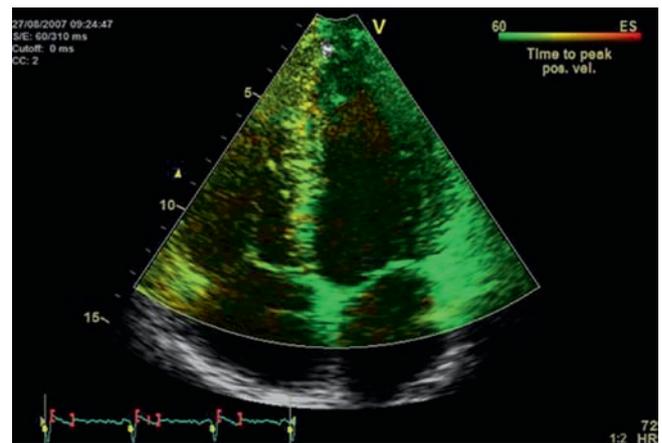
Tissue synchronization imaging (TSI) colour map superimposed on apical 4-chamber view in a normal subject. In the upper left corner, the time-to-peak colour scale is shown. The time delay is coded into different colours according to the severity of the delay in the sequence green, yellow, orange, and red. The homogeneous green and yellowish colours in this patient show a synchronous mechanical activation in both ventricles
